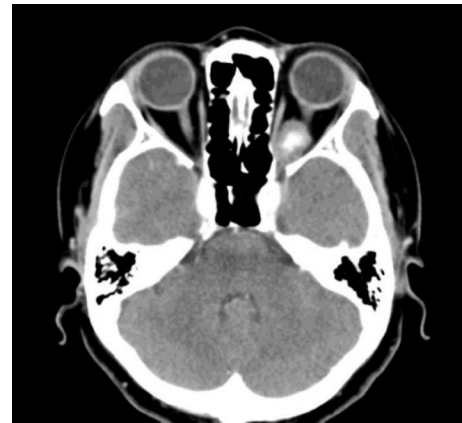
The CT scan indicated an inferomedial intraconal tumor about 14 × 17 –mm² in size located deep in the orbital apex compressing the optic nerve laterally and superiorly.
